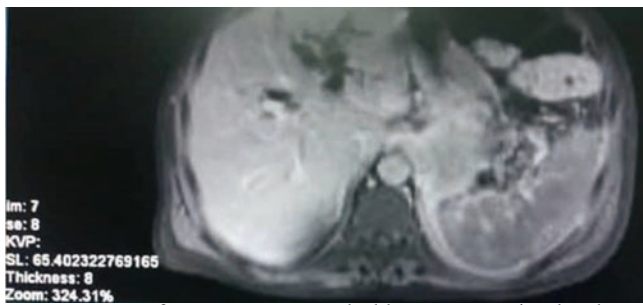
MRI of pancreas. Pancreas had heterogenous signal and were enlarged.
